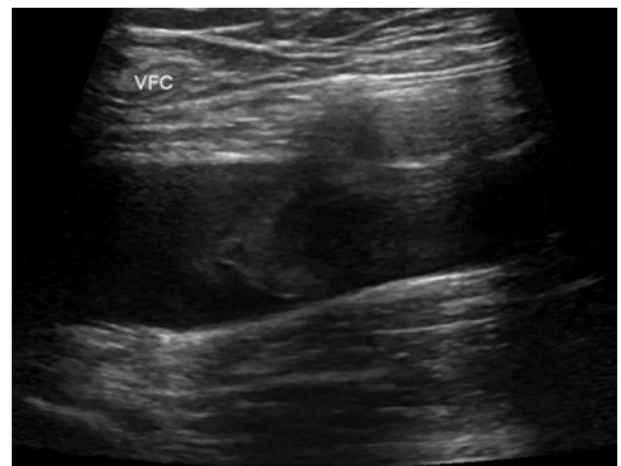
Left femoropopliteal vein thrombosis confirmed on doppler ultrasound after the patient started chemotherapy.
